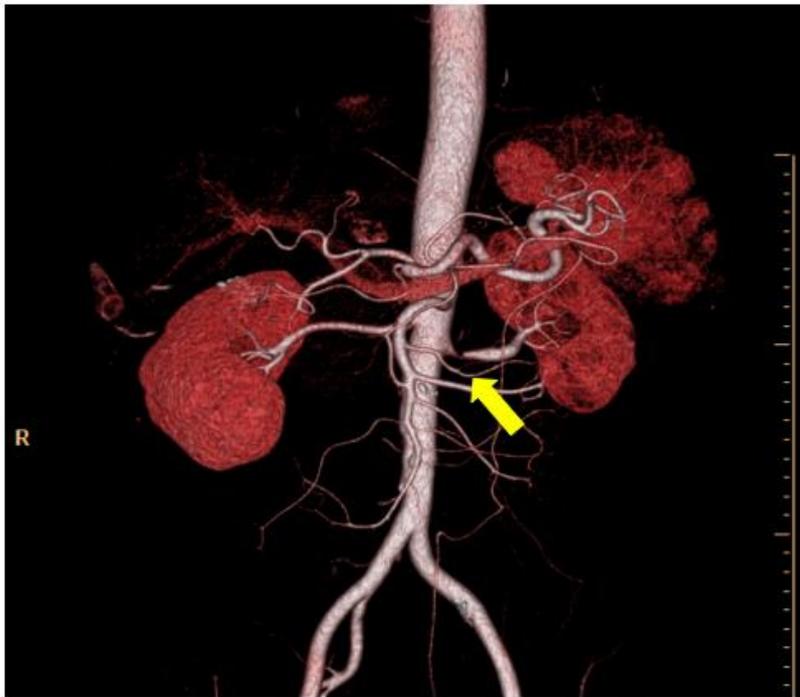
Abdomen renal angio CT showed focal severe stenosis in the left proximal renal artery(arrow)
